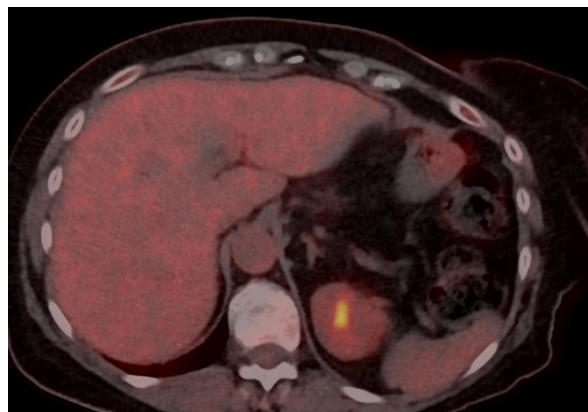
Follow-up PET-CT during the treatment with TDxd, showing complete disappearance of the liver lesion, the other liver lesions were also disappeared.
